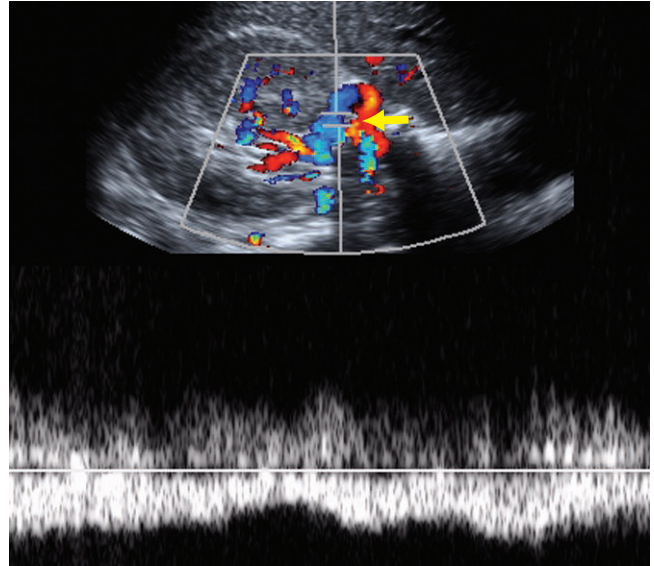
The transverse duplex and color Doppler image shows multiple tortuous, tubular channels in the vicinity of the main right renal vein on color Doppler (arrow). A venous waveform was obtained in one of these venous collaterals.
